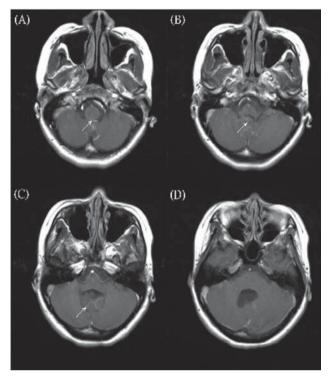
MRI of brain (T1WI with contrast) on May 13, 2011 showed tumor mass over 4th ventricle with dilatation.
